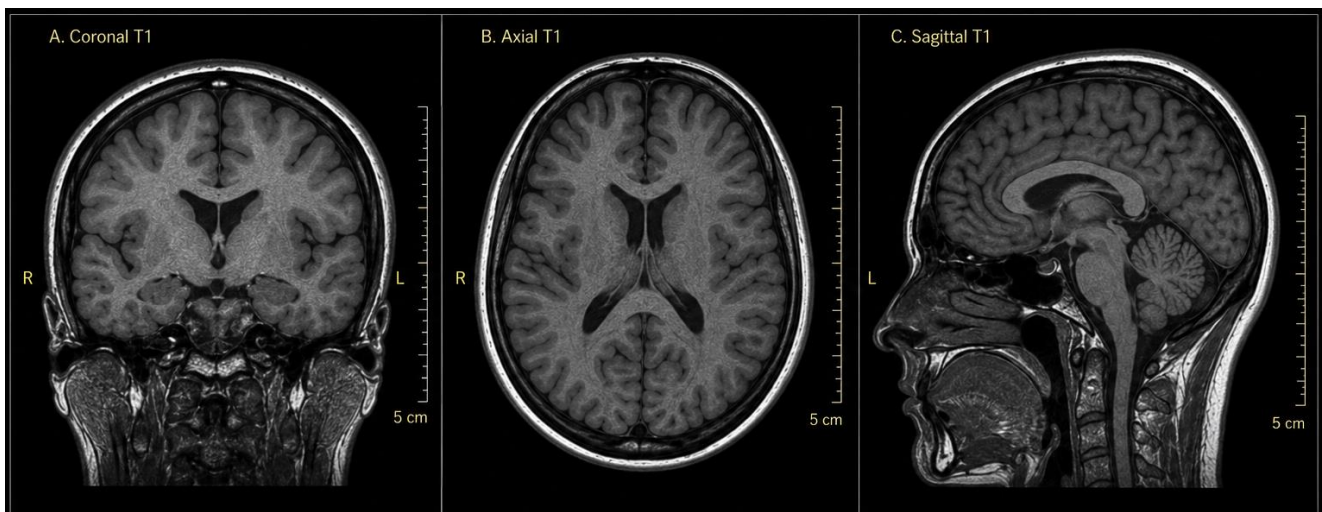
Coronal (A), axial (B), and sagittal (C) T1-weighted MRI views of the brain demonstrating normal cortical and subcortical anatomy. The cerebral hemispheres were symmetrical, the ventricles were of normal size and configuration, and no structural abnormalities were evident in the frontal or temporal lobes. These findings support the absence of organic pathology contributing to the patient's somatic delusions.
